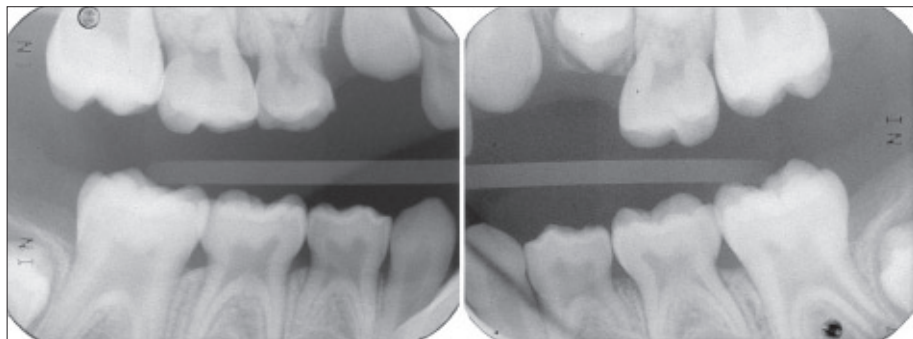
Bite-wing radiographs taken on June 12, 2003, of the patient's right and left side at age 7 years, 8 months.
